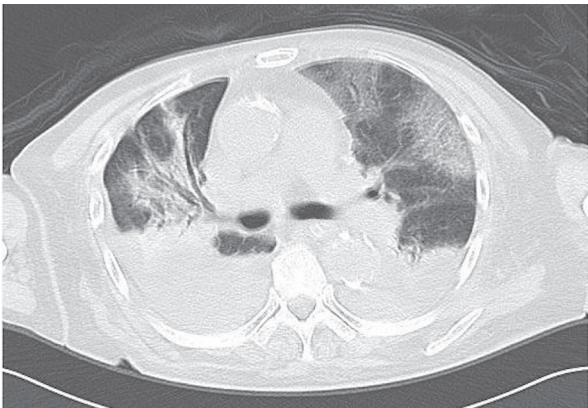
Chest computed tomography revealed a ground-glass opacity with interlobular septal thickening in non-dependent parts, atelectasis in dependent parts, and bilateral pleural effusions. (The patient was irritable during the examination in which the motion artifact was noted.)
